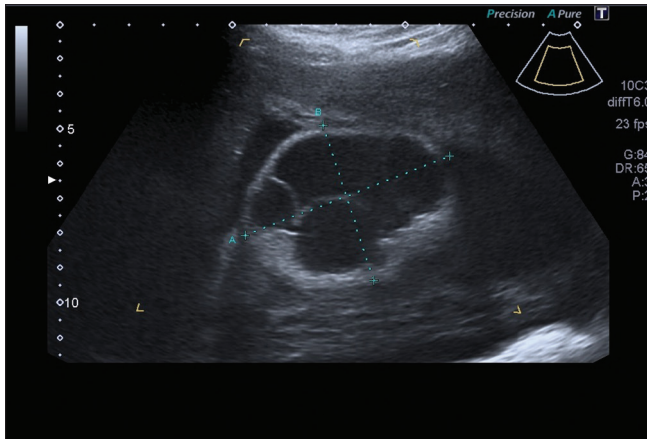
Twenty-one-week ultrasound: Transverse plane of fetal thorax showing a multilocular tumefaction
